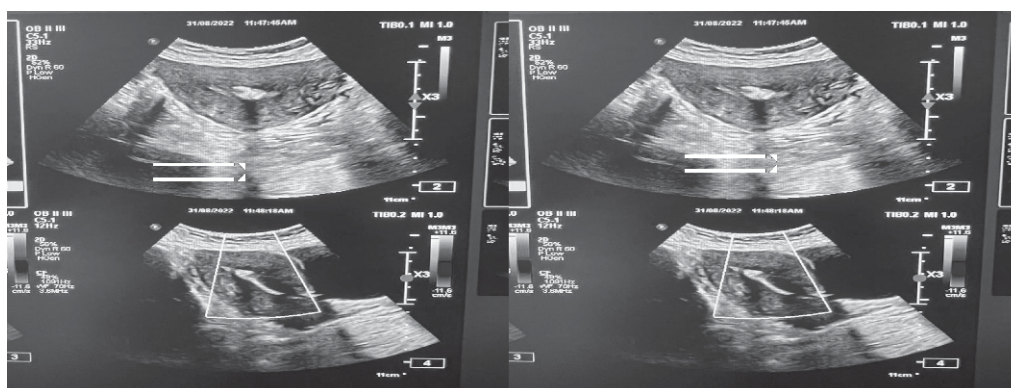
Trans-abdominal ultrasound showing linear calcifications in the uterine cavity
